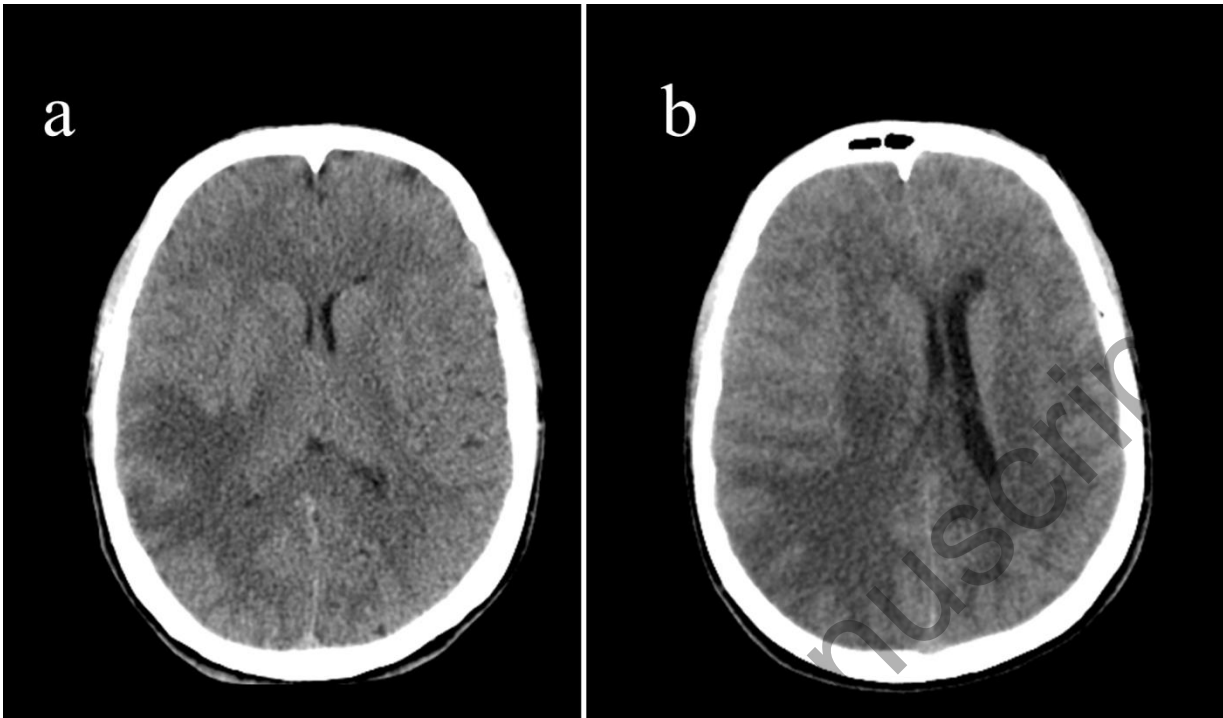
Head CT scan, axial view: a) first CT head scan performed on day 41 showing moderate vasogenic edema in the right temporo-fronto-parietal region and modest midline shift b) second CT scan performed on day 42 shows increasing vasogenic oedema in the right temporo-fronto-parietal region with extension to the capsular region, to the cerebral peduncle and in the ipsilateral mesencephalic region. Severe compressive effect on the right lateral ventricle.
